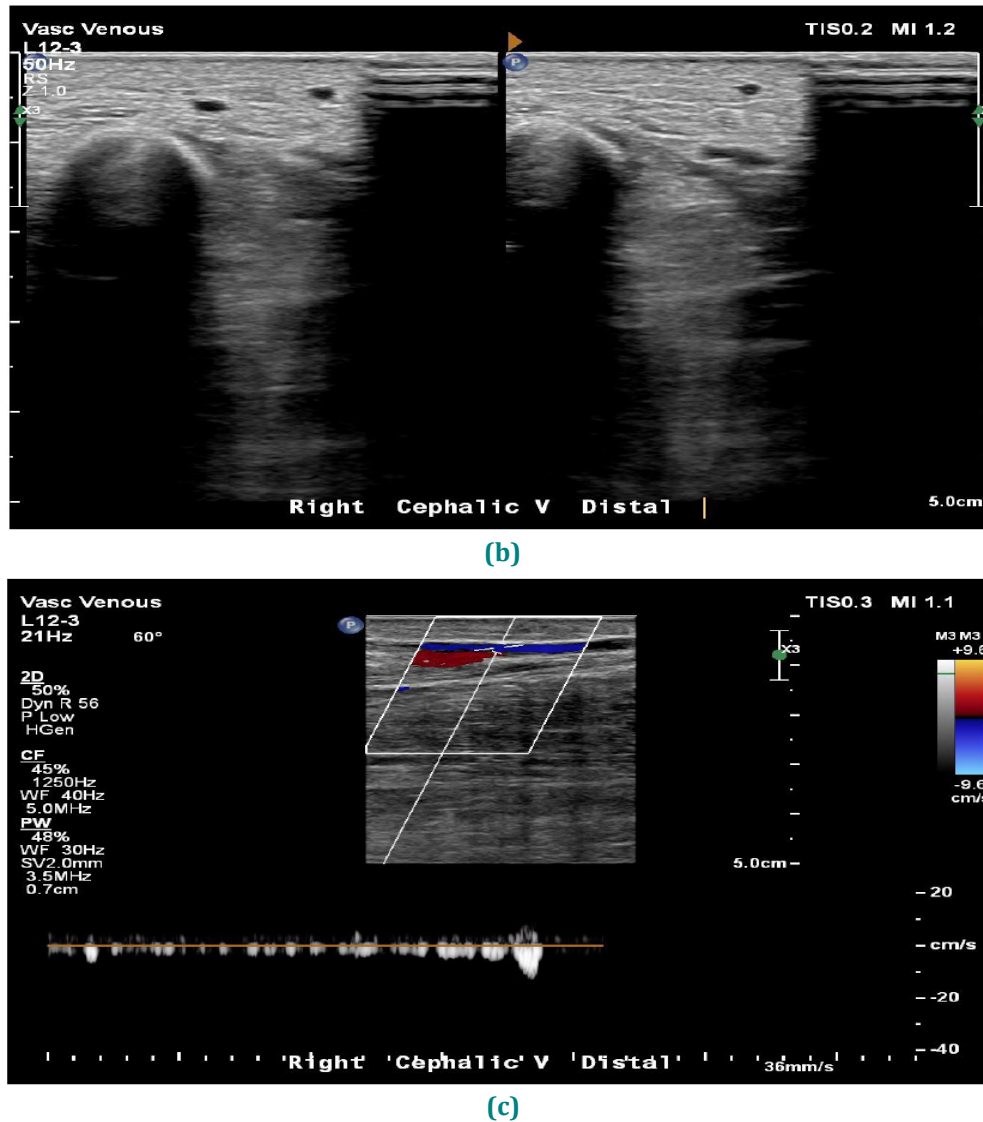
Sonographic image of the cephalic vein in Patient B (a) proximal (b) distal (c) color Doppler and pulse wave spectrum. Note the total compressibility and flow within the lumen which is suggestive of no clot
